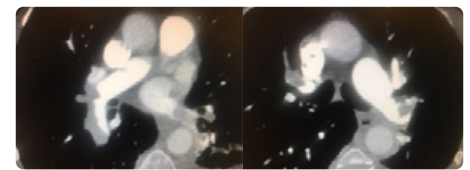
CT pulmonary angiography showing extensive thrombus involving the left and right pulmonary arteries.
